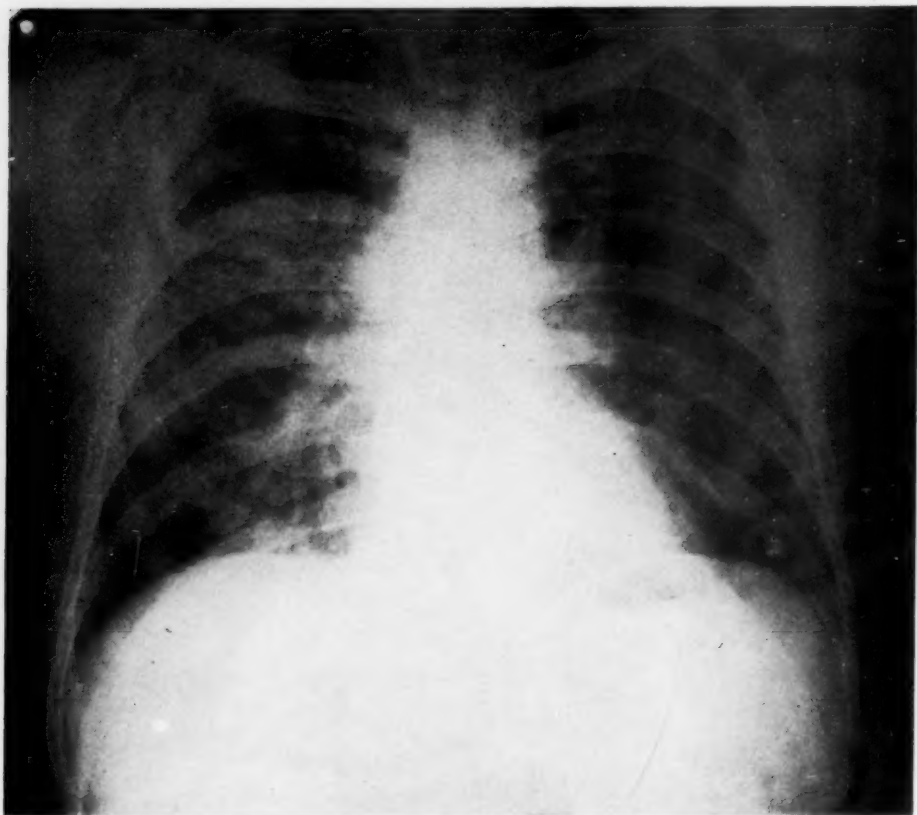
(Case 5.) Roentgenogram taken August 18, 1939. Considerable clearing of the infiltration throughout the left lung. Reappearance of infiltration in the right lung.
